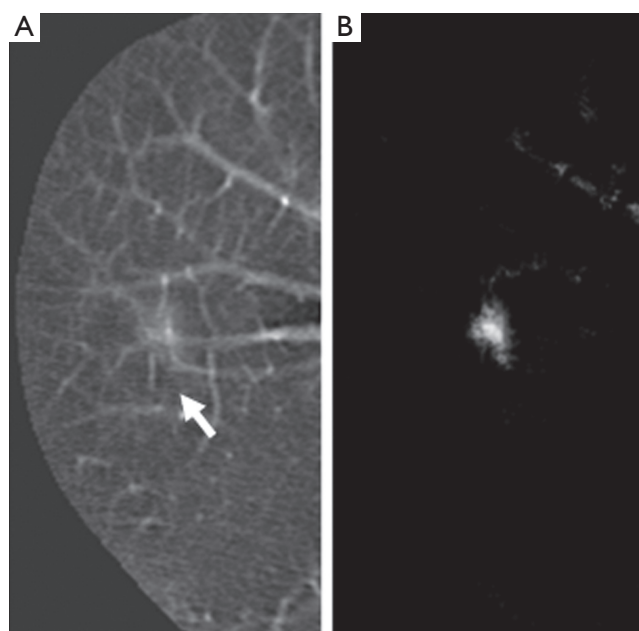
Lesion enhancement by means of a supervised MTANN lesion-enhancement filter. (A) Original axial CT slice with a lung nodule (indicated by an arrow). (B) Output image of the trained MTANN nodule-enhancement filter. In the output image (B), the lung nodule in the original CT image (A) is enhanced, whereas normal structures such as lung vessels are suppressed substantially
